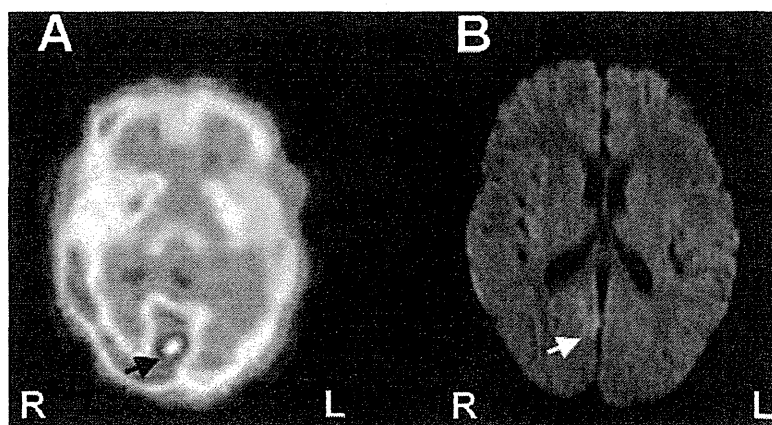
Brain imaging of a 7-year-6-month-old boy with AERRPS. (A) Ictal ^{99m}Tc -ECD SPECT of the brain performed at the 3rd hospital day revealing a circumscribed area of hyperperfusion (arrow) in the medial region of the right occipital lobe. (B) Diffusion-weighted brain MRI (TR 3500, TE 90) performed at the 4th hospital day revealing a high-intensity area (arrow) located in the same region as that on ^{99m}Tc -ECD SPECT, suggestive of cytogenic edema closely related to the seizure focus.
